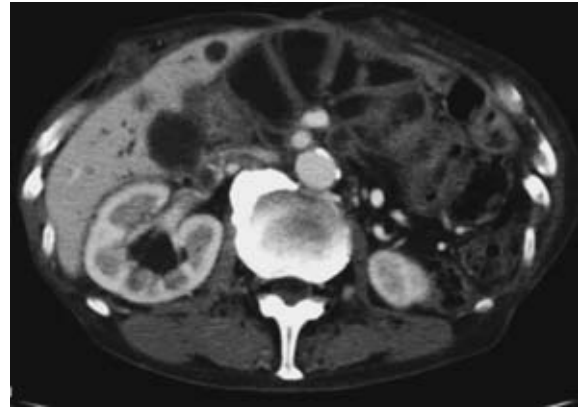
Ultrasonography and abdominal computed tomography revealed dilated loops, biliary ductal dilatation, and multiple masses in the liver.
